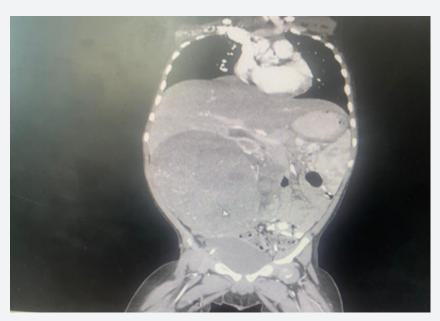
CT showing a huge heterogeneous mass (arrowed).
